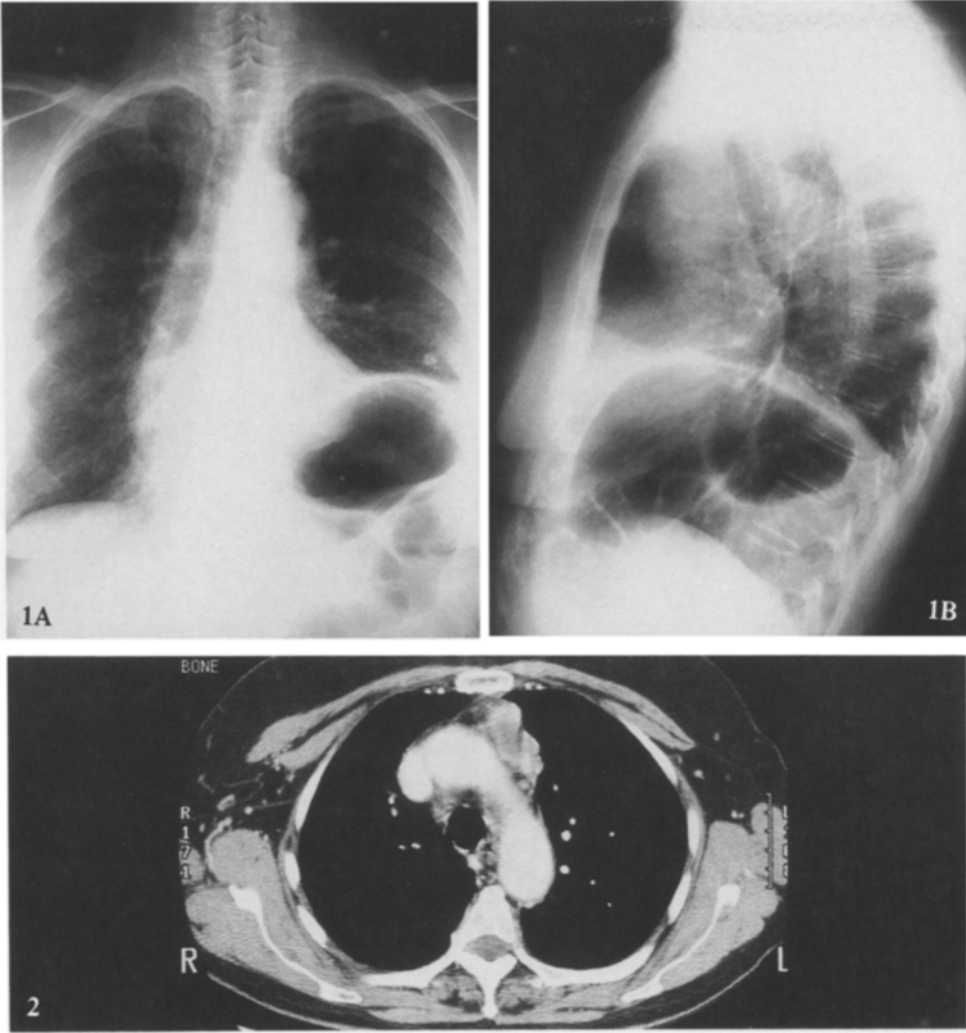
Postero-anterior (A) and lateral (B) chest radiographs revealing an elevated left hemidiaphragm. The postero-anterior radiograph shows a mass overlying the aortic arch.
